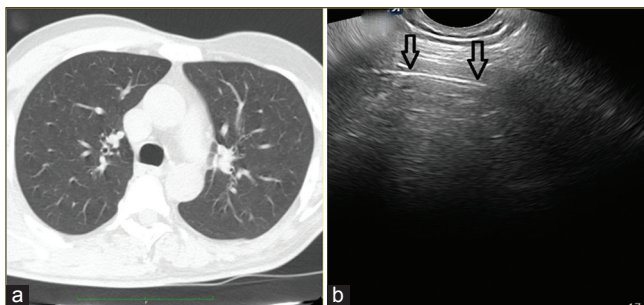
(a) High resolution computed sonography: Normal. (b) Transthoracic ultrasonography: Normal hyperechoic pleural line (black arrow). No B-lines visible
